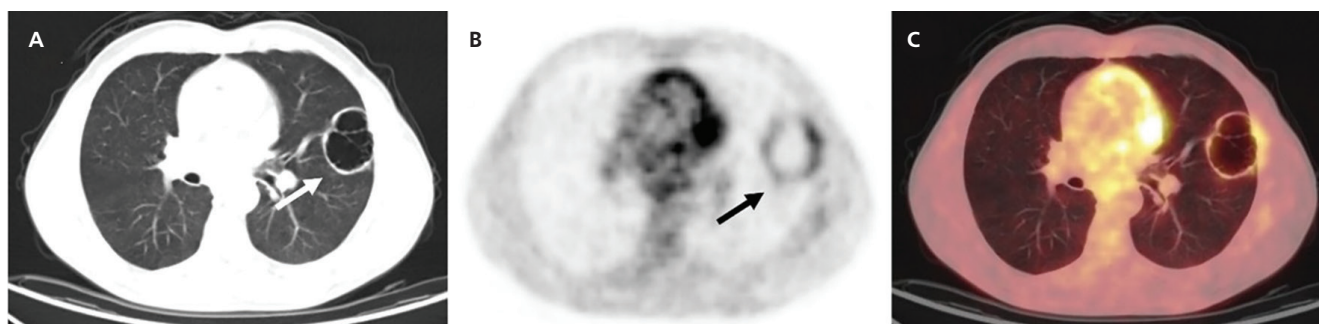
Squamous cell carcinoma. Axial CT (A), ^{18}F -FDG PET (B), and fused PET/CT (C) images show a cavitary mass lesion with mild ^{18}F -FDG uptake, measuring approximately 55 mm in the longest axial diameter, with a maximum wall thickness of 6 mm and an SUV_{max} of 4.22 (arrows)
